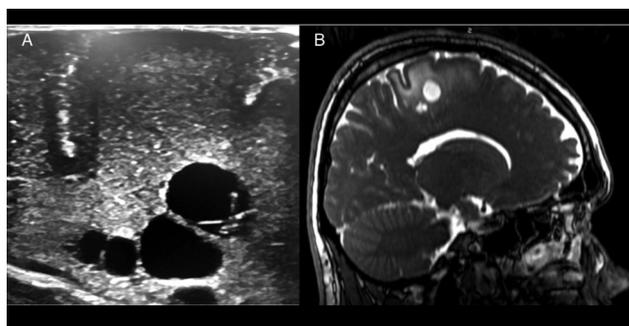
Intraoperative US image of a cystic lesion located in the precentral gyrus and its relation to preoperative MRI. Note the relation of the larger cyst with the shallow precentral sulcus that is visible in both US image (A) and MRI (B), as well as the relation with the smaller lesion with the deeper central sulcus. To obtain this image, the transducer is placed parallel to the midline, giving a sagittal view. MRI, magnetic resonance imaging; US, ultrasound.
